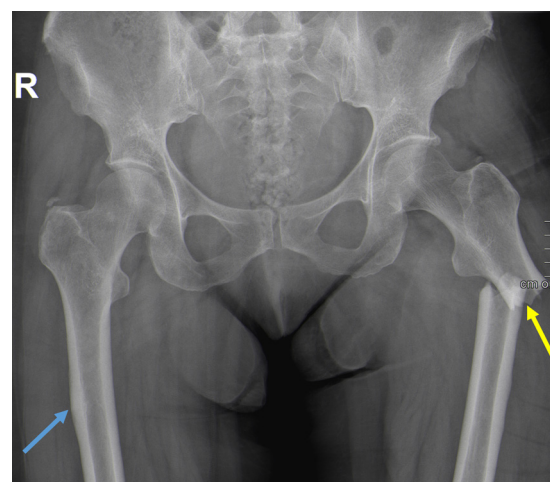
Pelvic radiograph demonstrates a subtrochanteric fracture of the left femoral diaphysis (yellow arrow), typical of a bisphosphonate-related atypical fracture. Lateral cortical thickening of the right femur in a subtrochanteric location is also present (blue arrow).
